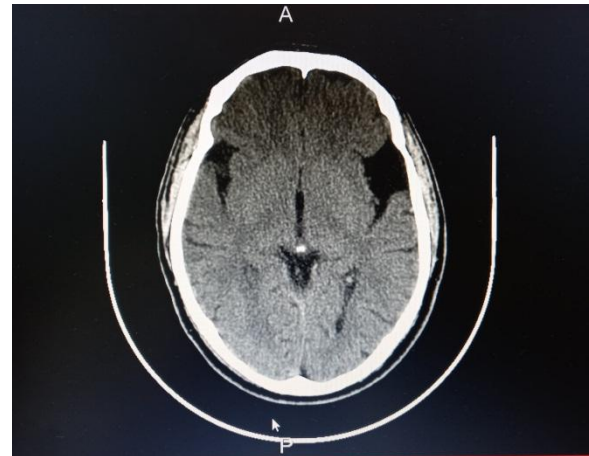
Computed Tomography Scan of the brain without contrast showing Arachnoid cyst at left temporal lobe.
